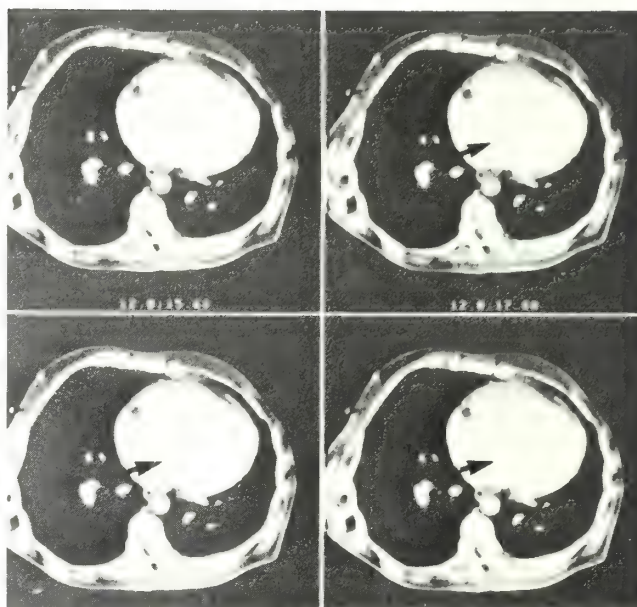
Cine-CT study of large VSD (arrow) with right to left shunt.
